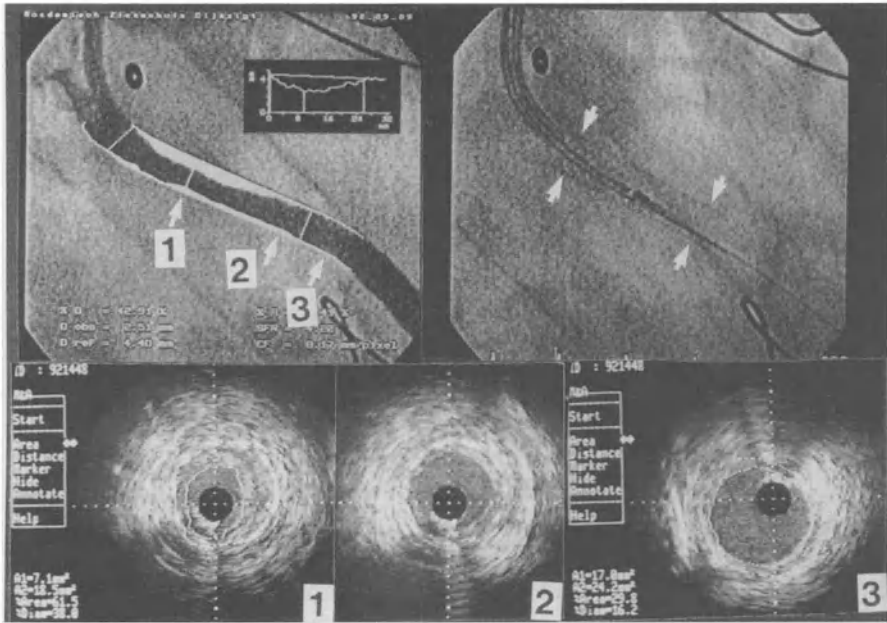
Digital angiogram of a Palmaz-Schatz stent 4 months after implantation in a saphenous vein graft used as aorto-coronary bypass conduit. In the fluoroscopic image the poorly radioopaque stent, indicated with arrows, is examined with a 4.3 rotating mirror ultrasound catheter. The minimal lumen of the moderate (re-)stenosis observed within the stent (position 1) corresponds with ultrasound to a homogeneous area of poorly echogenic intimal thickening. Note that intravascular ultrasound in this case overestimates the minimal luminal cross-sectional area (4.94 mm² with angiography vs 7.10 mm² with ultrasound). A diffuse area of intimal thickening within the stent is detected also in position 2, a relatively normal segment angiographically. Calibration: 0.5 mm.
